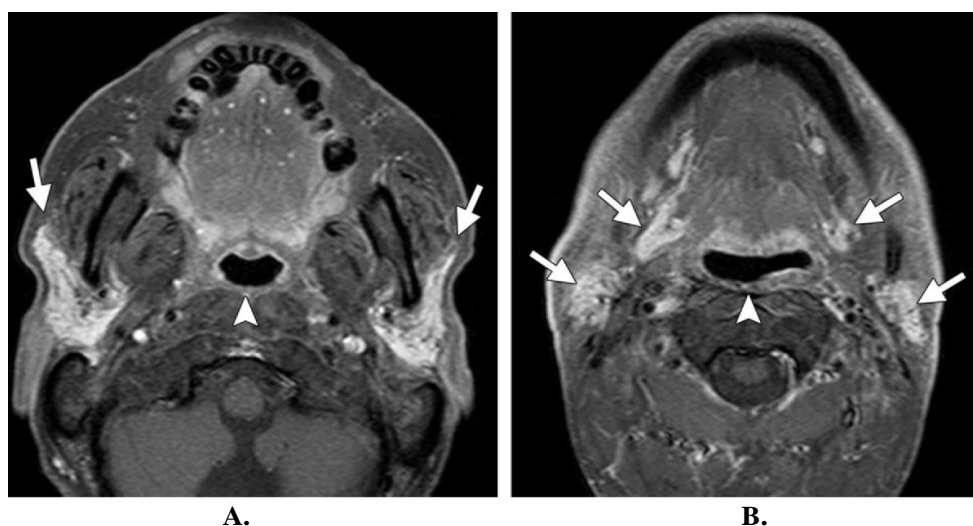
Late post irradiation changes at 1year after completion of radiation therapy in a 70-year-old man with squamous cell carcinoma of the buccal mucosa and hypopharynx. Contrast-enhanced fat-saturated T1-weighted MR images (A. At the level of the oropharynx and B. At the level of the base of the tongue) show atrophy of the parotid and sub-mandibular glands (arrows) and thickening of the pharyngeal constrictor muscle (arrowhead) and skin.
